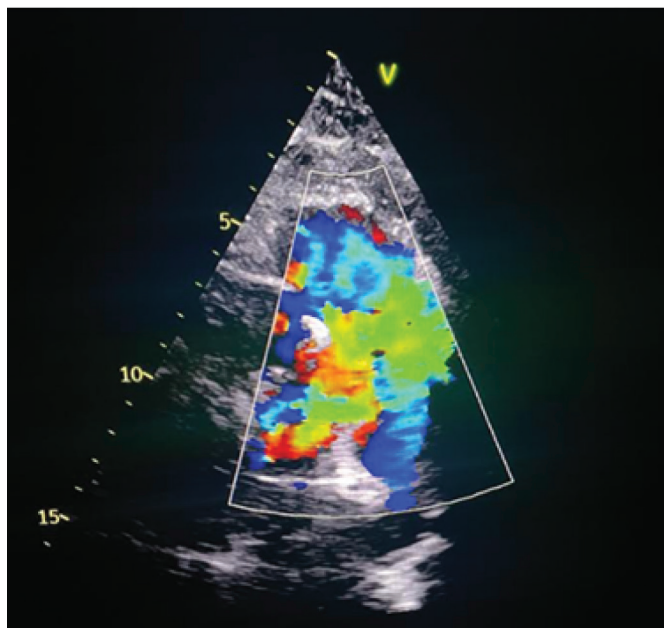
23-year-old man: Color Doppler of the right ventricular outflow tract and branch pulmonary arteries in parasternal short axis view with the retrograde flow originating from the distal branch pulmonary arteries.
